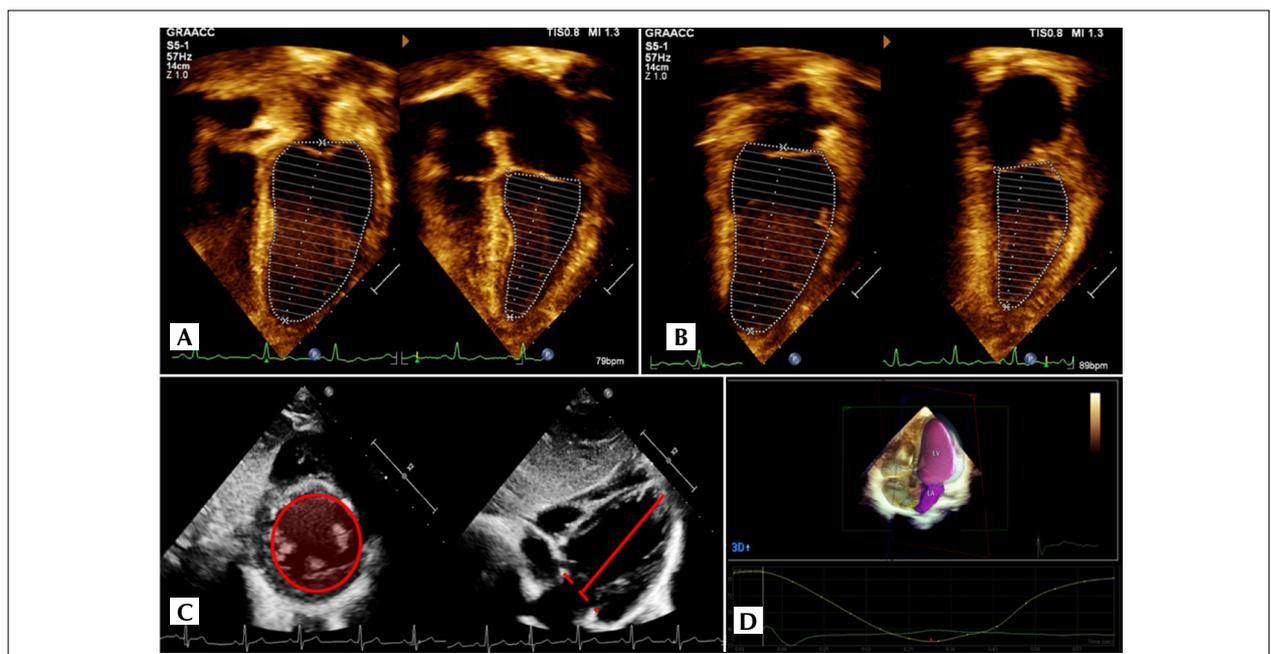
(A, B) Biplane Simpson's method. Apical four- (A) and two-chamber (B) left ventricular volumetric analysis. (C) Area-length or bullseye method used to determine left ventricular ejection fraction (LVEF). (D) LVEF analysis performed using the three-dimensional method.
